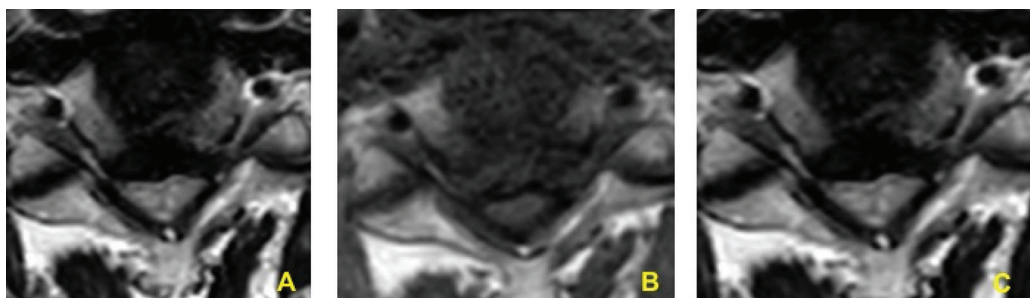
An 80-year-old male patient with gait disturbance. MRI shows grade 3 cervical neural foramen stenosis (severe CNFS) bilaterally in (A) axial 2D T2W image, (B) axial 3D T1W image, and (C) axial 3D T2W image.
